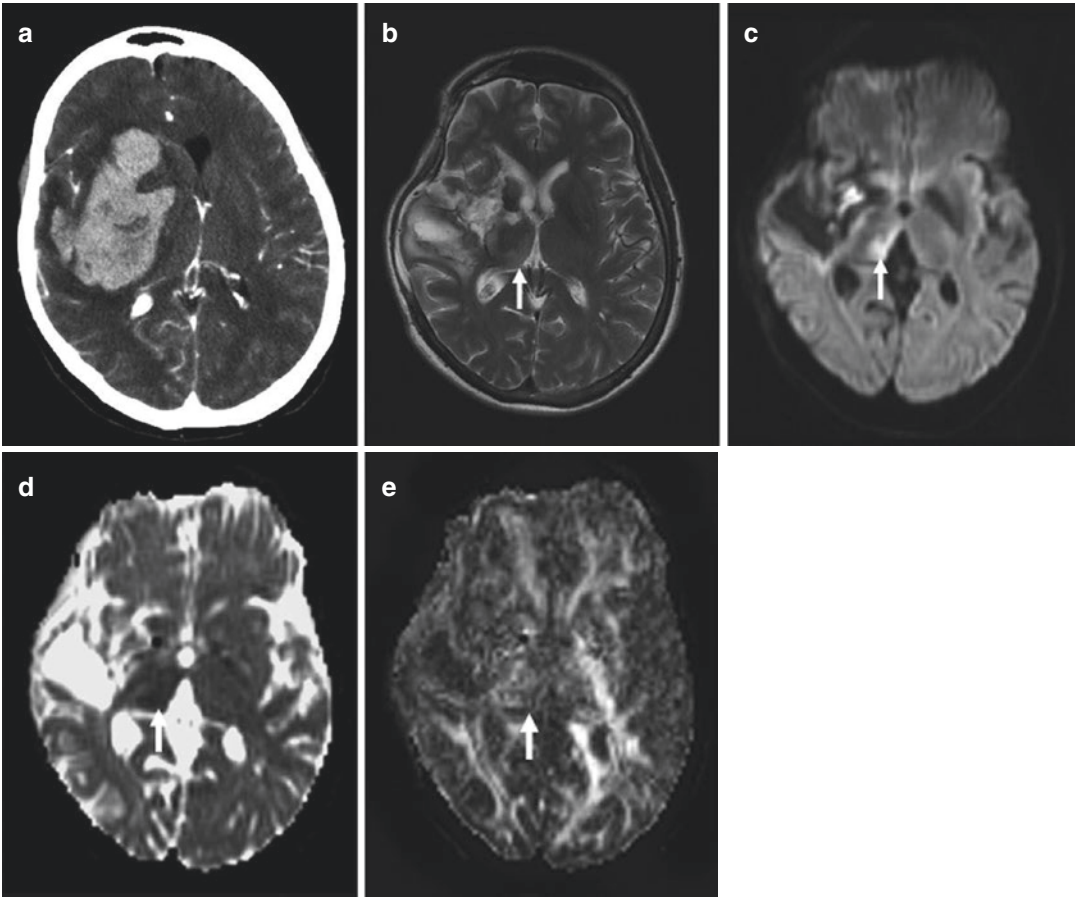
Retrograde degeneration in the dorsomedial thalamus in a 56-year-old woman with right large putaminal hemorrhage. (a) Postcontrast CT shows a large hematoma in the right putamen extending into the frontotemporal region with edema and a mass effect. (b) The 2-month follow-up T2-weighted image shows a high signal intensity in the dorsomedial thalamus (*arrow*).
